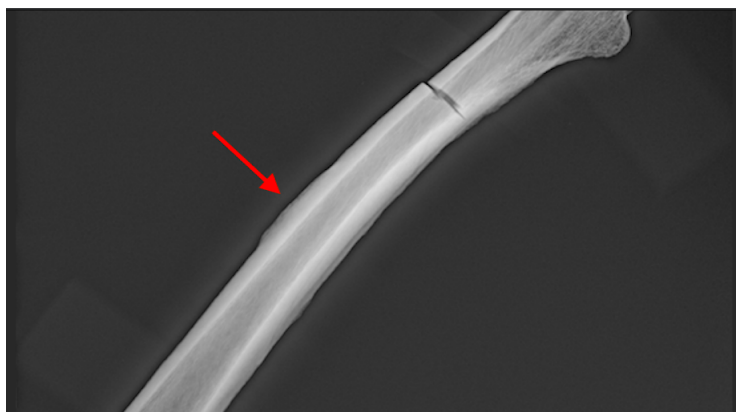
Nr.13, InvNr 27974, Grave ID 312: x-ray of the left femur. The red arrow shows the affected area and that the compact bone was not affected by the impression (photographed by A.Wagner)
